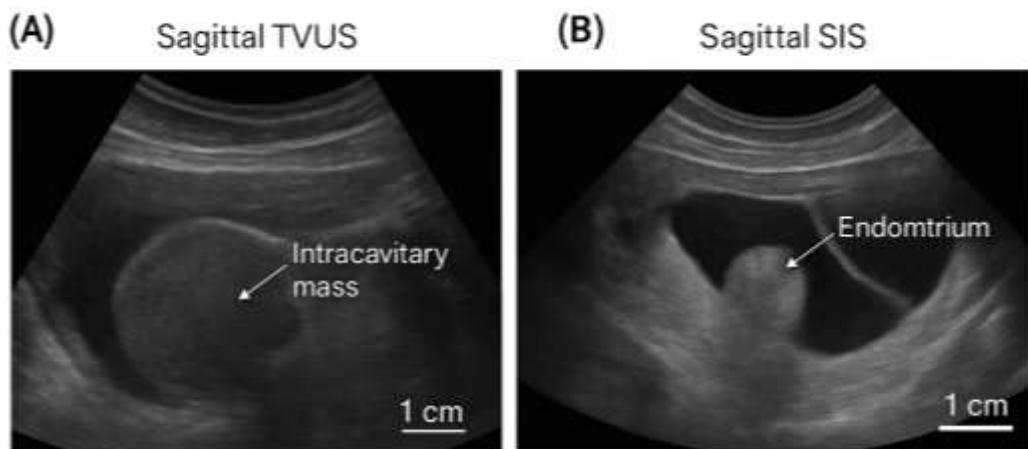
Transvaginal ultrasound (sagittal) and saline-infusion
